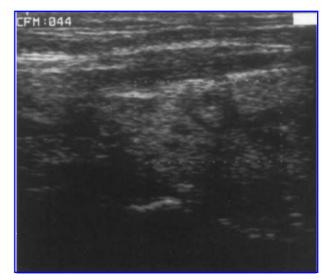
Doppler scan, absence of vascular flow at the end of the laser thermal ablation (LTA) treatment.
